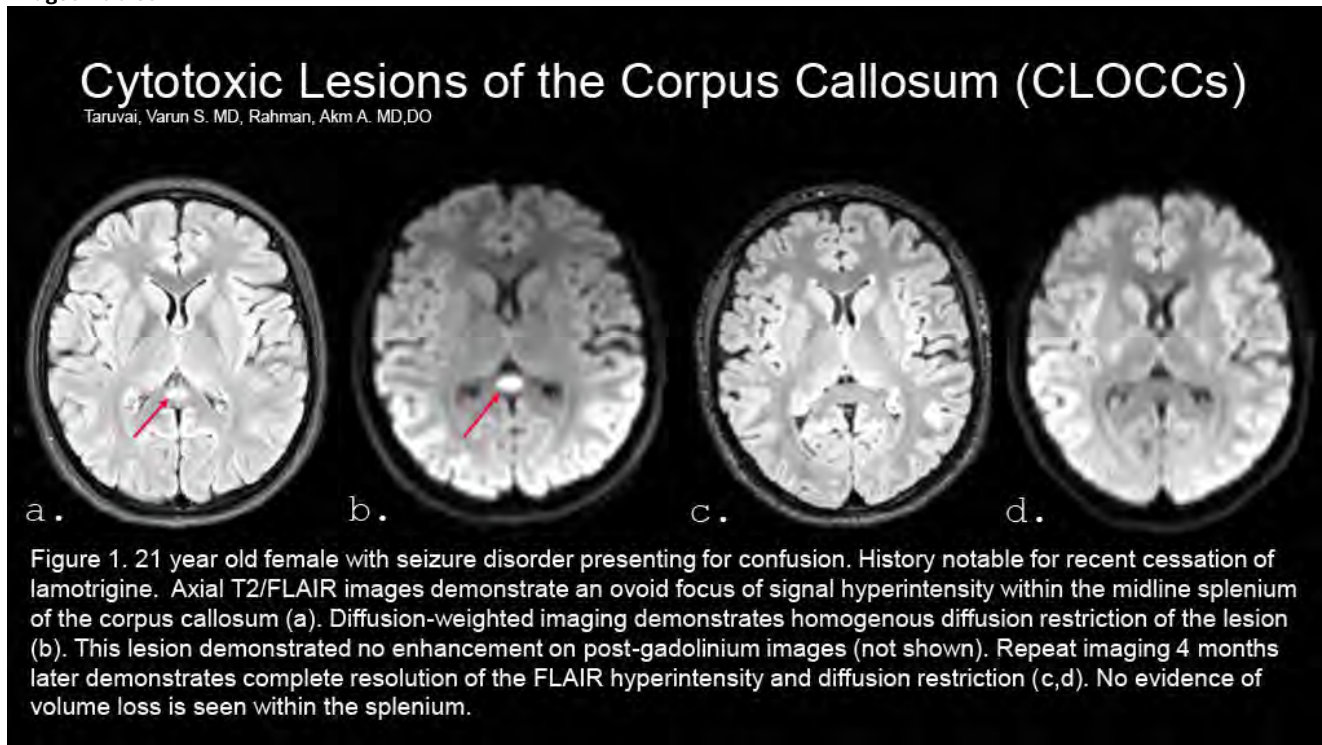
21 year old female with seizure disorder presenting for confusion. History notable for recent cessation of lamotrigine. Axial T2/FLAIR images demonstrate an ovoid focus of signal hyperintensity within the midline splenium of the corpus callosum (a). Diffusion-weighted imaging demonstrates homogenous diffusion restriction of the lesion (b). This lesion demonstrated no enhancement on post-gadolinium images (not shown). Repeat imaging 4 months later demonstrates complete resolution of the FLAIR hyperintensity and diffusion restriction (c,d). No evidence of volume loss is seen within the splenium.
